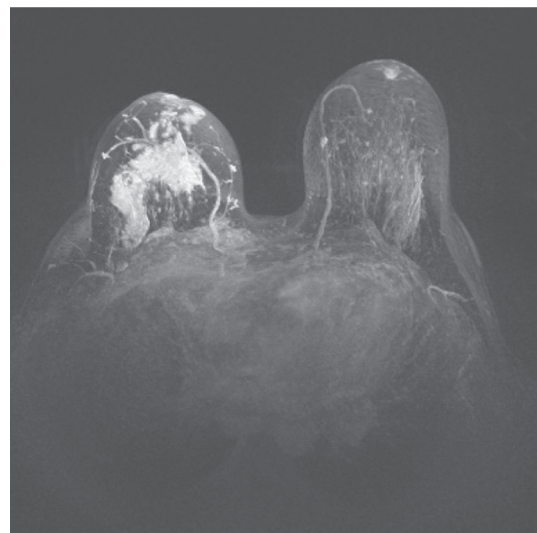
Breast MRI, T1 with contrast and subtraction in MIP axial image, showing 2 adherent large irregular shaped enhancing masses in the right breast with multiple smaller masses around them in favor of multi-centric breast cancer
